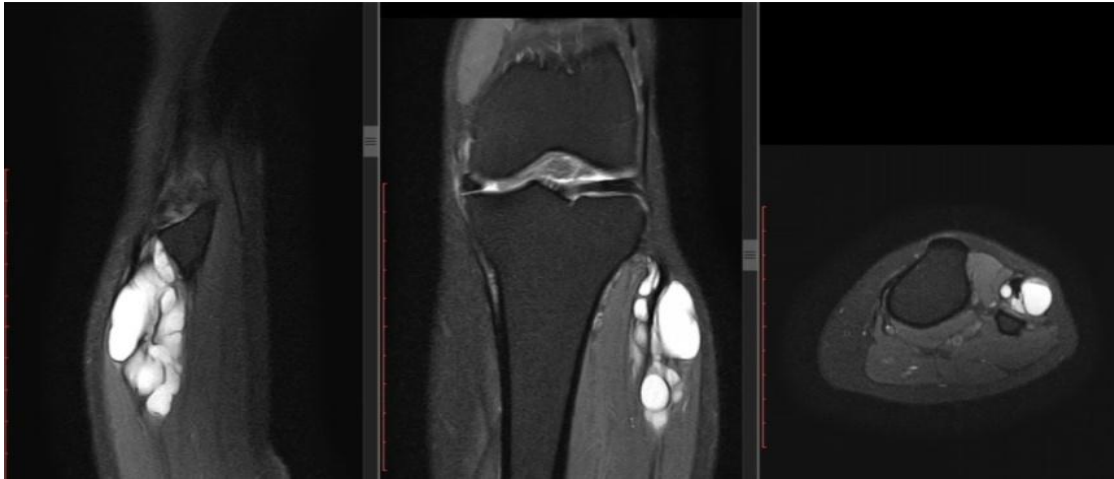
Sagittal, coronal and axial T2 weighted MR images showing multiloculated cystic lesion at level of the neck of fibula, lying in the muscular plane with no communication to the joint
